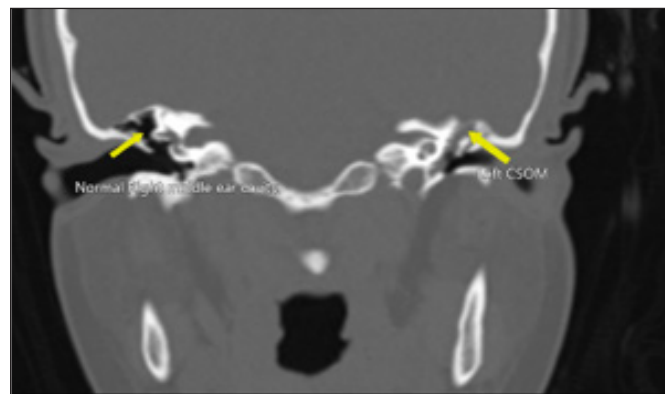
Two coronal sections through a CT scan of the paranasal sinuses of the same patient show the presence of opacification in the left middle ear cavity completely encasing the ossicular chain suggesting otitis media. The left mastoid air cells are also completely opacified demonstrating fluid density consistent with acute left mastoiditis.
